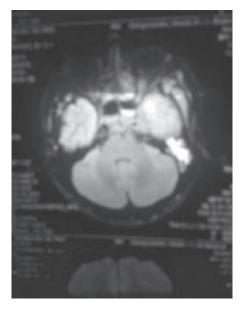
FLAIR MRI Image with hyperintense area are noted in the left middle era and mastoid region
